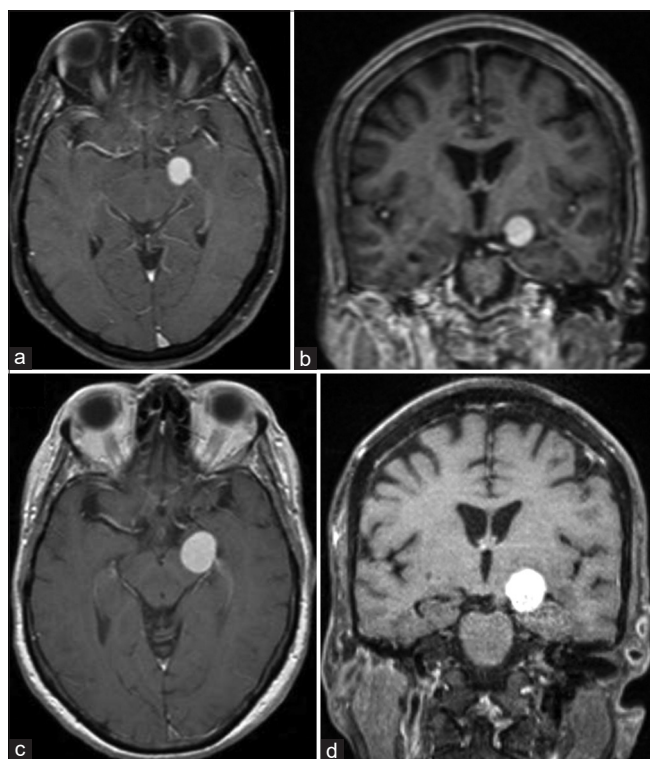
(a) Axial plane contrast-enhanced MRI demonstrating lesion at time of initial presentation. (b) Coronal plane contrast-enhanced MRI demonstrating lesion at time of initial presentation. (c) Axial plane contrast-enhanced MRI demonstrating interval growth 1 month after initial presentation. (d) Coronal plane contrast-enhanced MRI demonstrating interval growth 1 month after initial presentation.
